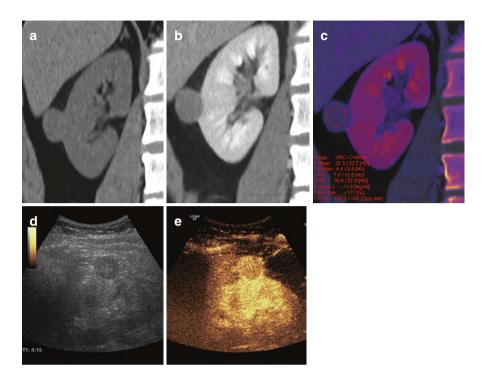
Coronal CT image before (a) and after (b) contrast medium administration showed a 2 cm well-circumscribed exophitic right kidney mass with uncertain enhancement (HU values: unenhenced scan 21; nephrographic 39). This features could represent both cystic or solid mass. Coronal DECT color-coded iodine overlay image (c) showed iodine content (1 mgI/ml on ROI), thus demonstrating a hypo-vascularized lesion. Gray-scale US image (d) demonstrates a solid hypoechoic mass and CEUS (e) clearly shows a mild and homogeneous enhancement. The final diagnosis was a p-RCC
